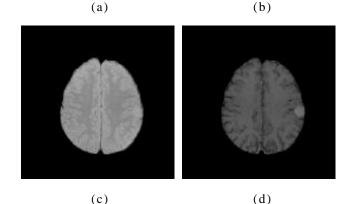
The MR images of the brain. Axial section. (a) T1-weighted image; (b) T2-weighted image; (c) Proton density image; (d) Gd-DTPA
